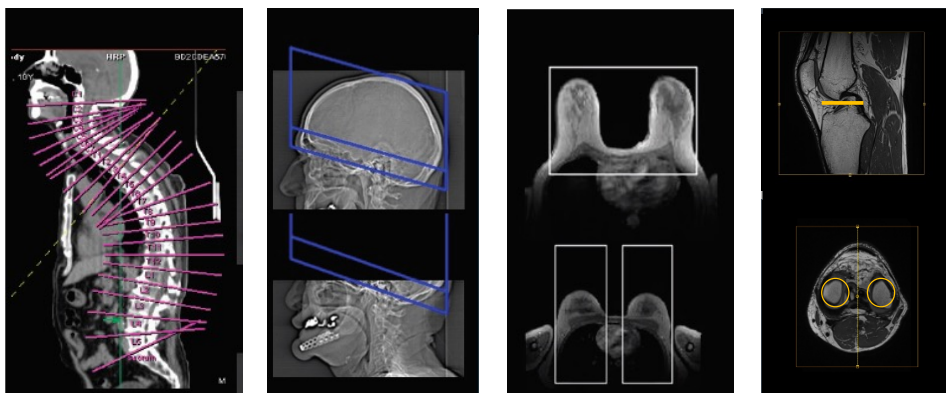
(a) ALPHA, example of how it works. (b) ALPHA detects various anatomical structures to assist the acquisition or reading of medical images. Several examples from left to right of the image demonstrate robustness of ALPHA technology: automatic vertebra localization and labelling performed to provide planes at C1-C7, T1-T12, L1-L5, S (abnormal patient positioning); results for head scan ranges—the lower edge should go through the canthomeatal line (works even when full anatomy is not present); detection of bounding boxes around the breast or separately for right and left breast regions on MRI images; plane alignment for optimal imaging of the menisci in MRI images.
